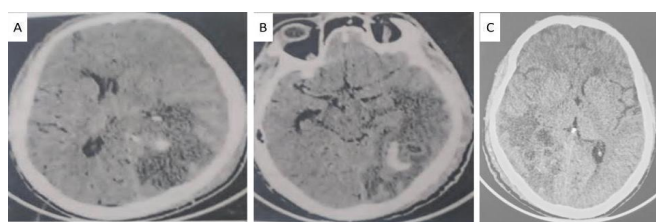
Computed tomography (CT) images of the patient in different time intervals. A and B: NCCT head of the patient at the time of admission. Image showing multiple hypo dense lesions with surrounding edema in the right temporal parietal lobe with midline shift of 12.2 mm towards left side. C: NCCT head of the patient after burr hole surgery and 14 days of Liposomal Amphotericin B therapy. Image shows decrease in the midline shift to 7 mm.
